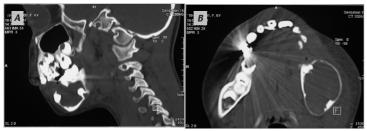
Computed tomography images. (A) Vertical CT image showing the well-defined lesion in the mandibular left region. (B) Axial CT image displaying the lesion surrounding the first and second premolar teeth.
